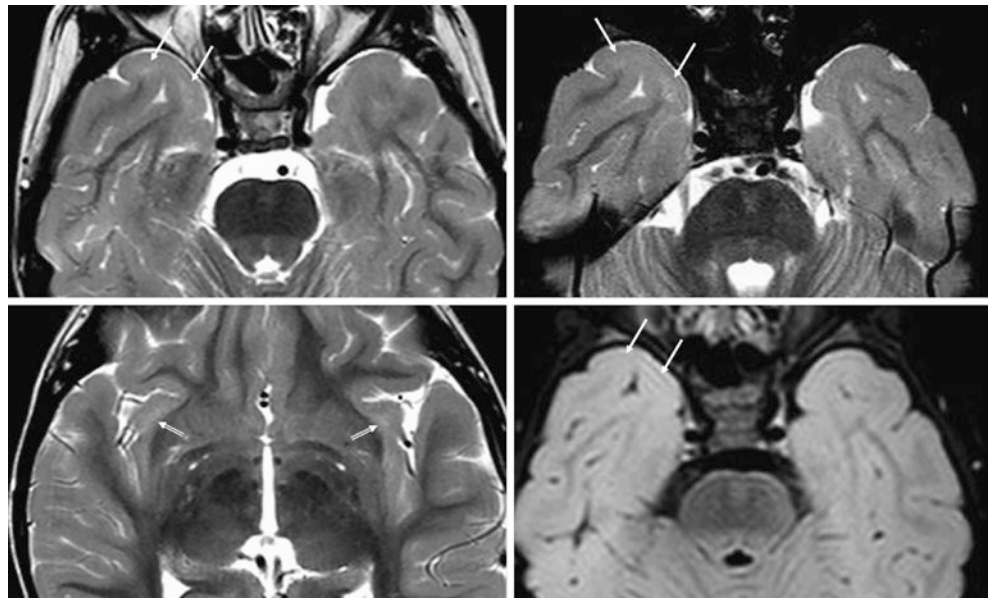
A 4.25-year-old with a concussion. Normal 3T axial SE T2WI with 5 mm (*top left*) and 3 mm thickness (*top right* and *bottom left*), as well as 3D FLAIR (*bottom right*). Note subtle terminal zones manifested as patchy anterior right temporal SCWM (*thin arrows*) on T2WI, which are hardly visible on FLAIR. Also, note bilateral SIWM terminal zones (*beveled arrows*, *bottom left*)
